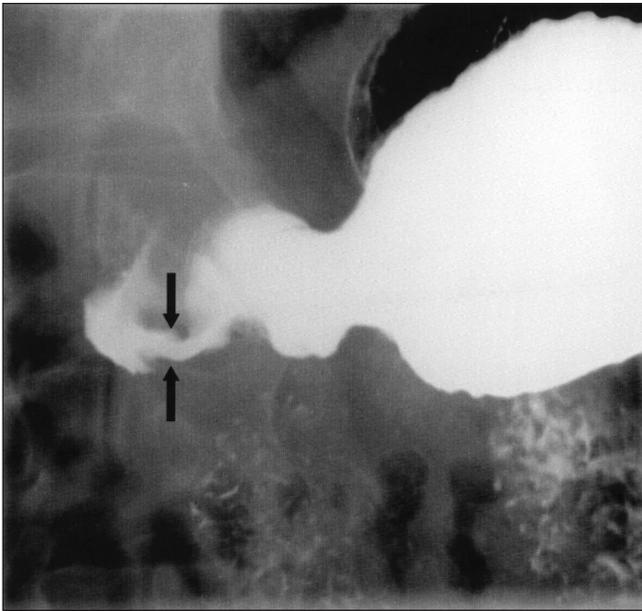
Barium contrast radiograph of the stomach demonstrating flow of barium through a patent pylorus (arrows) into the duodenum
